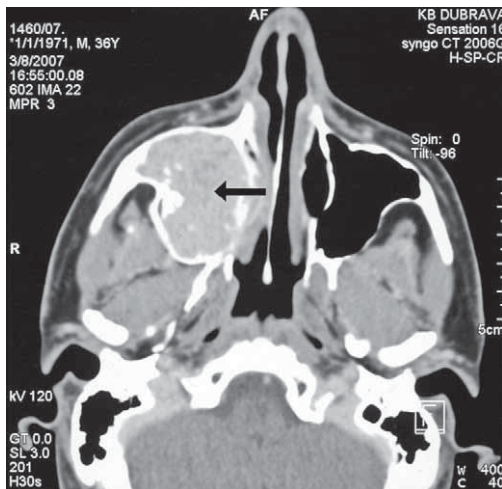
CT-scan showing tumor mass in the right maxillar sinus (horizontal view).
